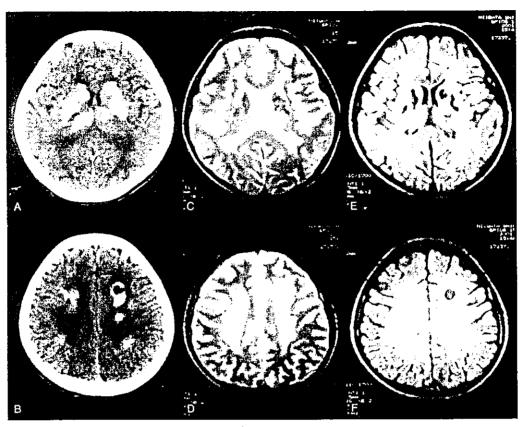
Brain CT and MRI findings. Brain CT (A, B) disclosed multiple calcifications and an isolated cystic lesion in the left frontal region. Low or null signals were observed in T₁, T₂ and FLAIR images of the areas in which calcification had been demonstrated on CT. High signals were seen in entire centrum semiovale, the white matter surrounding the lateral ventricles, and the left thalamic lesion in the T₂ and FLAIR images, in which no lesion had been demonstrated on CT. A, B: Brain CT. C, D: T₂-weighted images (TR 3600 ms/TE 110 ms). E, F: Fluid attenuation inversion recovery (FLAIR) method (TR 6650 ms/TE 110 ms).
